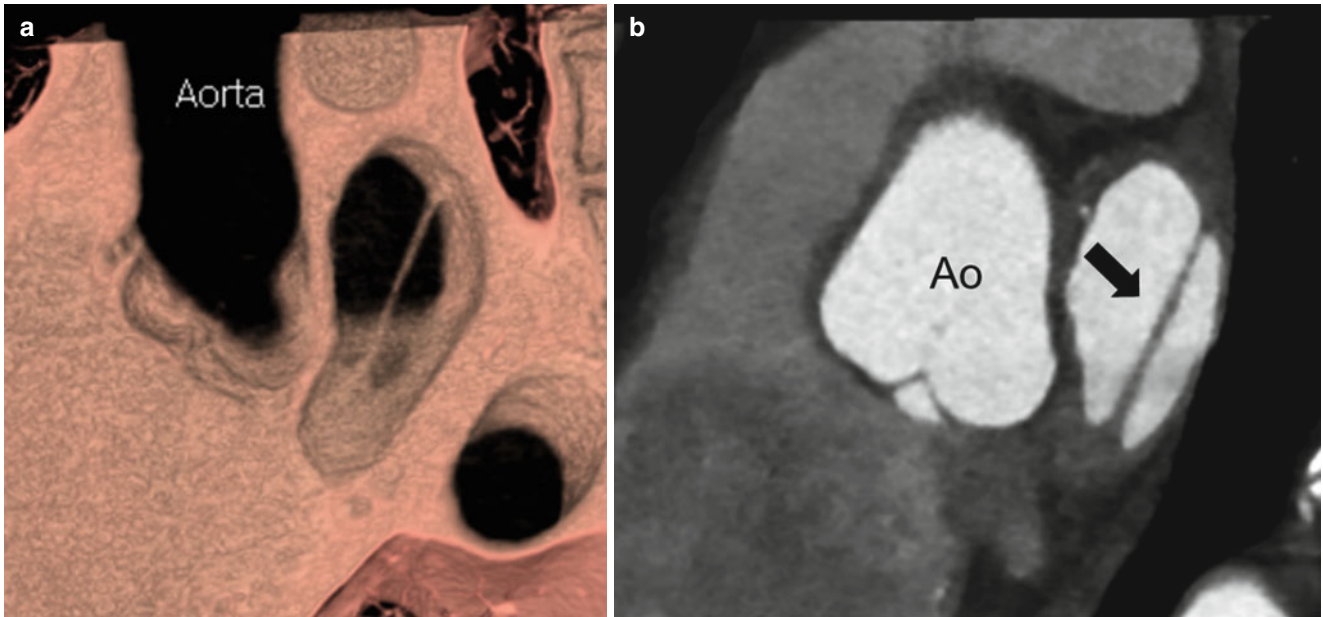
Cor triatriatum. Three-dimensional (a) and two-chamber view (b) CT images show a nonobstructive membrane or columnar structure as the cor triatriatum within the left atrial chamber
